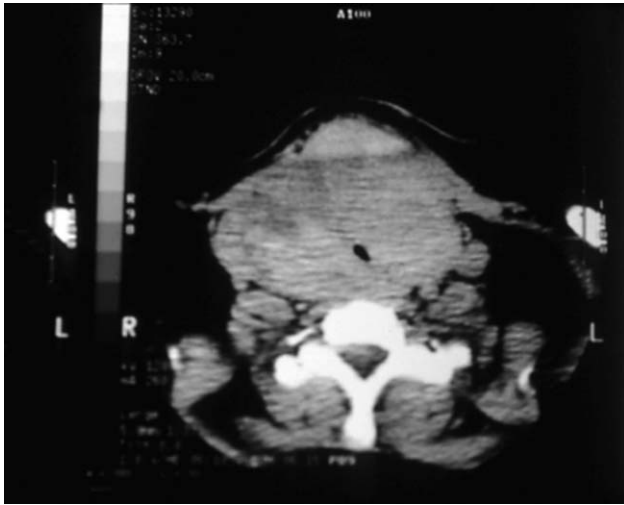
CT scan of a patient presenting with stridor after two previous bilateral thyroidectomies. Nerve monitoring was used during third revision total thyroidectomy and was found valuable. No tracheomalacia was present, airway symptoms resolved postoperatively, and tracheotomy was not needed. Cord motion was normal after surgery.
